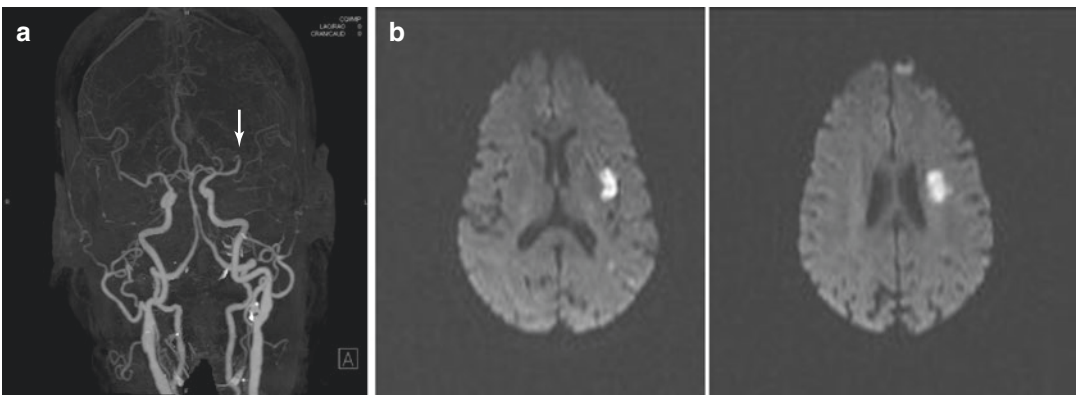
In situ thrombosis, middle cerebral artery (MCA). (a) Occlusion of left MCA (M1) on CT angiography. (b) Acute infarct of insular and striatocapsular region on diffusion-weighted image
